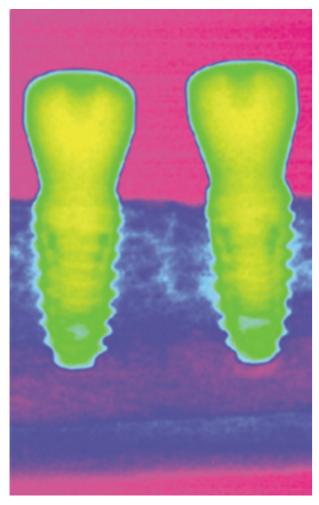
Gray scale color coding for radiographic analysis.
